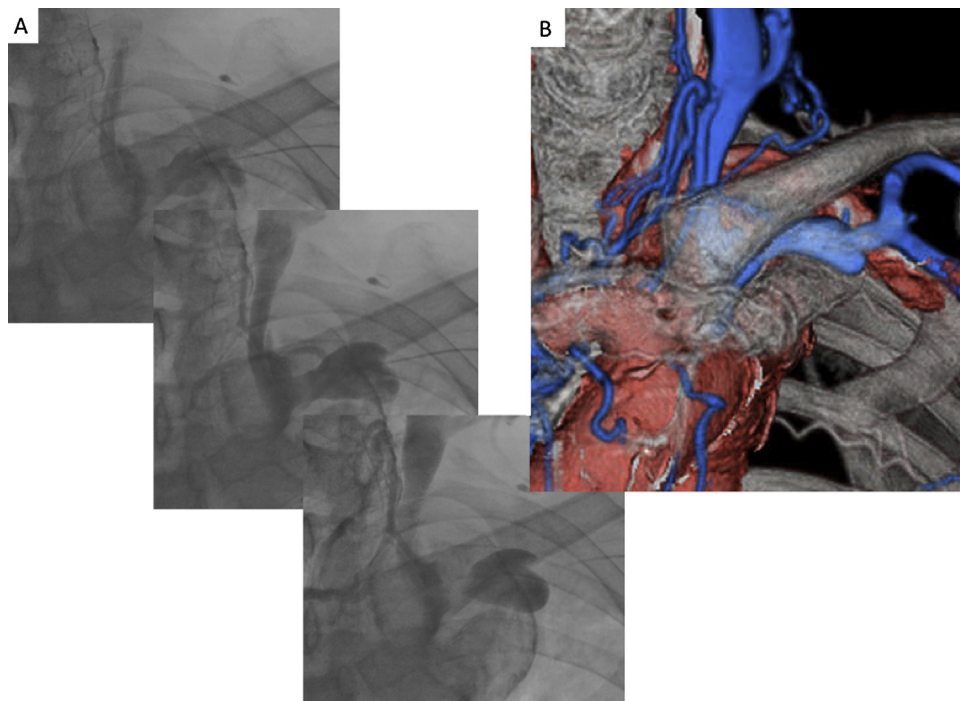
(A) Intra-procedural venography showing no left brachiocephalic vein and the development of collateral veins. (B) Three-dimensional reconstruction of the computed tomography of the chest showing a disruption of the beginning of the left brachiocephalic vein and the development of collateral veins as shown by venography.
